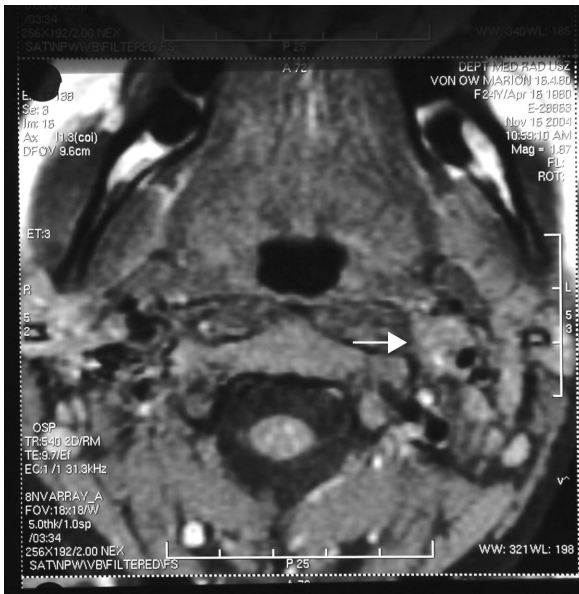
T1-weighted cervical magnetic resonance imaging with fat-suppression technique of left internal carotid artery dissection shows the intramural hematoma with intermediate signal intensity (white arrow) 2 days after symptom onset (early stage). (Courtesy Prof. Ralf W. Baumgartner).
